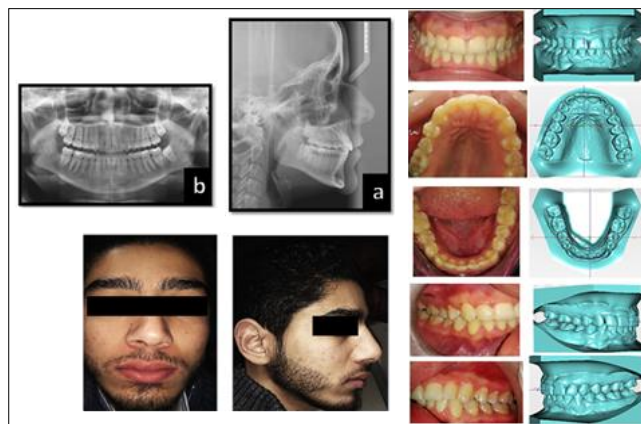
First patient: post-treatment photographs and radiographs
